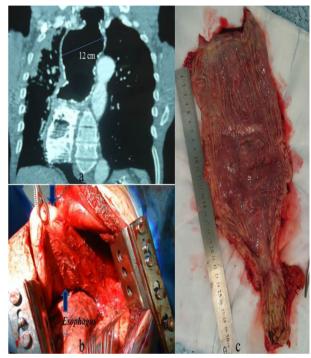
Pathology was seen to affect all the thoracic esophagus (CT scan) and Esophagectomy in B and C picture.
